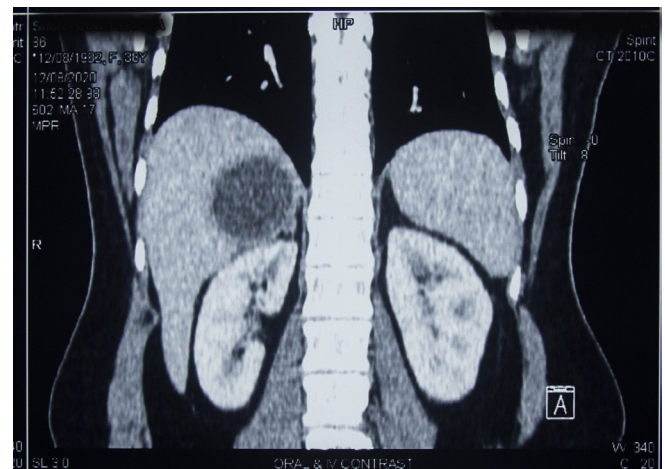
Contrast enhanced computed tomography showing a hypodense lesion affecting segment VII of liver.
